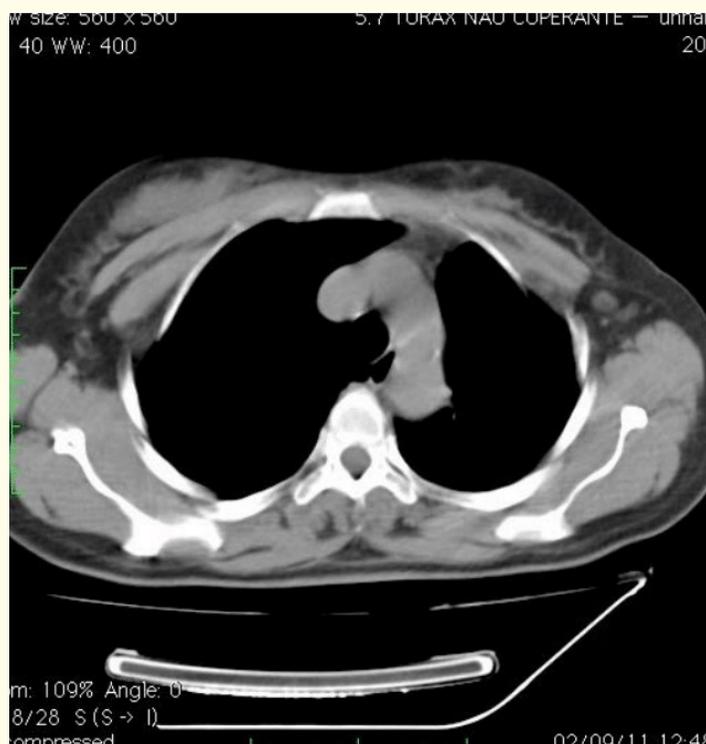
Post-operative CT scan image showing no evidence of tumor recurrence.
